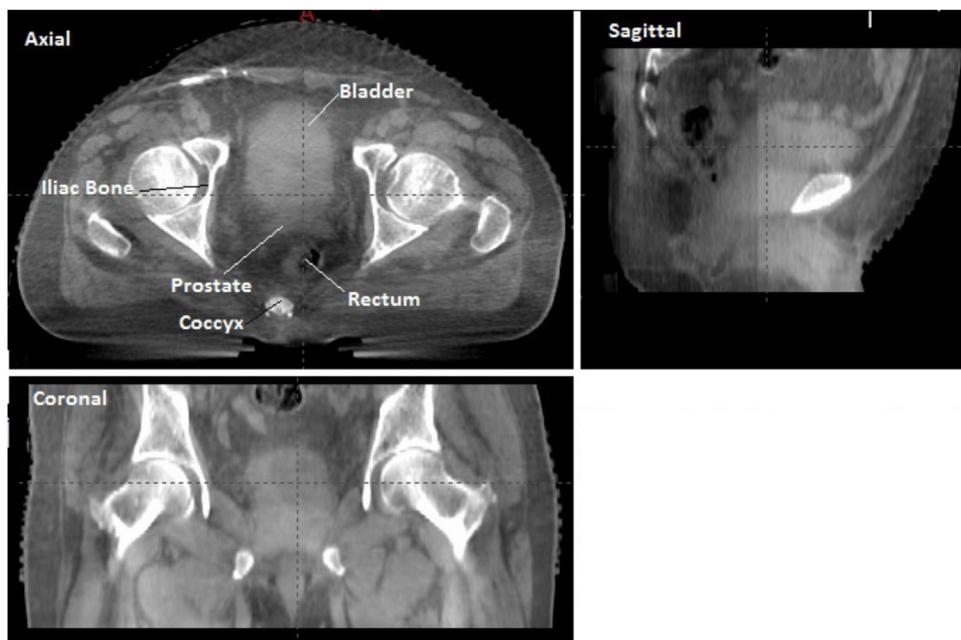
Axial, coronal and sagittal view of cone beam computed tomography (CBCT) images of one of the prostate cancer patient.
